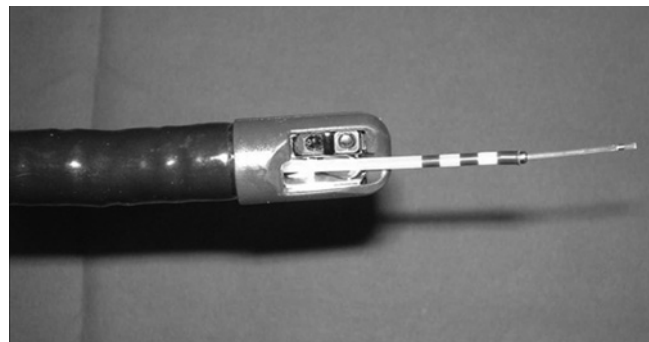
High-frequency ultrasound probe through the working channel of a side-view endoscope.
